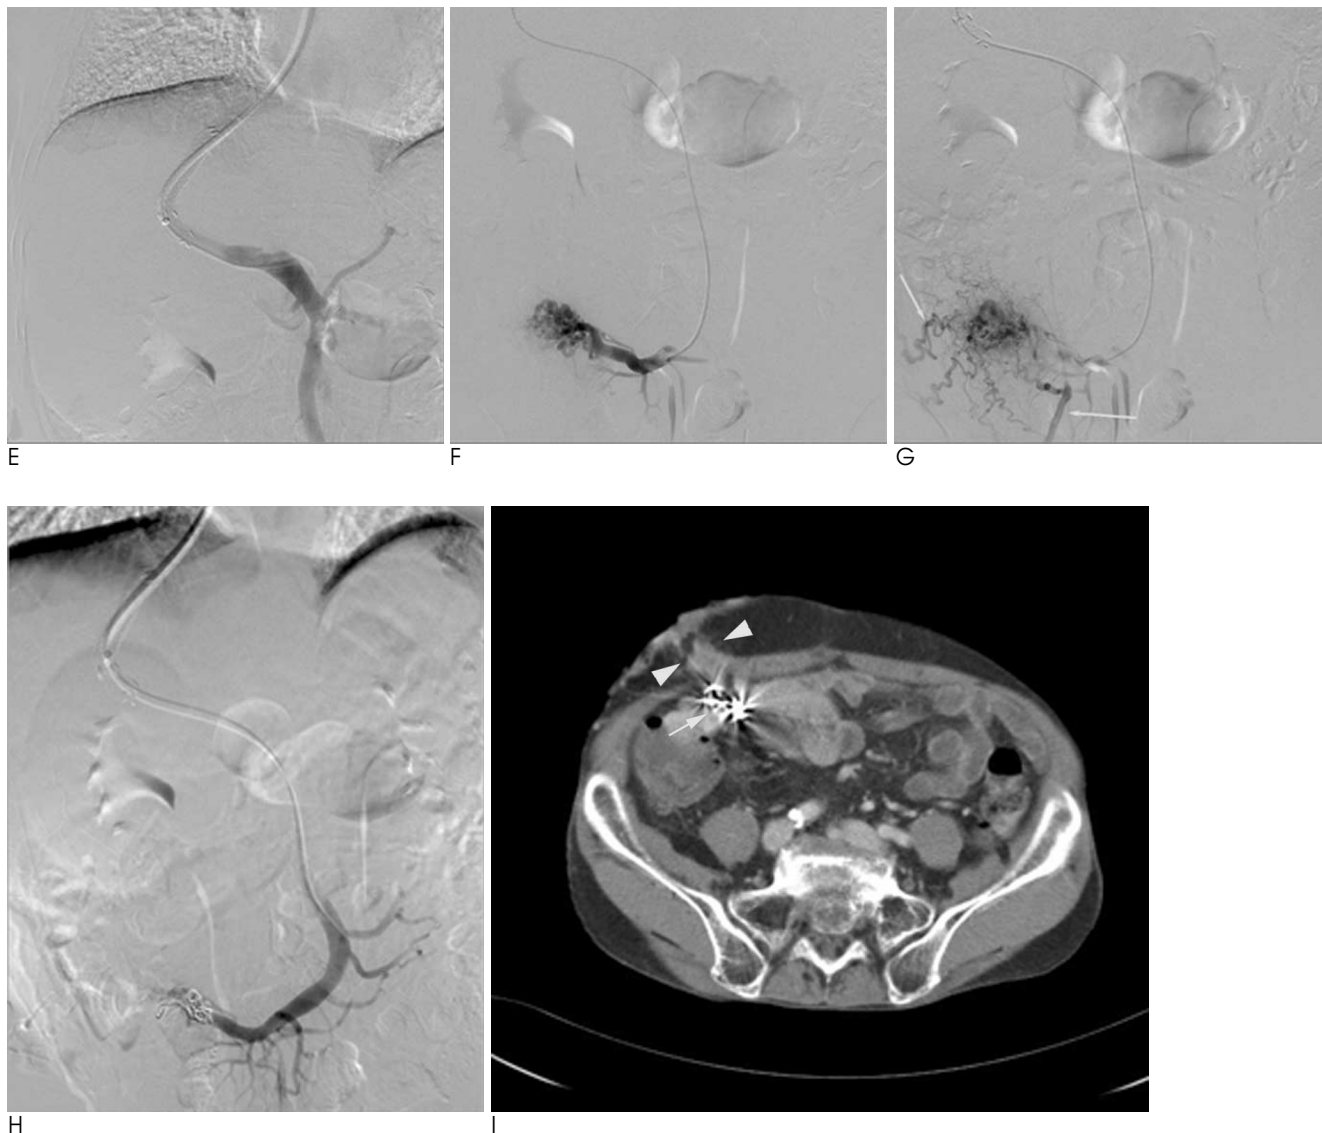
E-H. A subtracted transjugular portogram demonstrates the TIPS with coil embolization, in steps. (E) A portal venogram obtained after insertion of a TIPS stent-graft. (F) A well-developed stomal varix from an ileal branch of the superior mesenteric vein is noted. (G) A delayed image demonstrates systemic drainage (arrows) of the stomal varix. (H) After coil embolization of the stomal varix, there is no further bleeding and systemic drainage. I. The patient visited the hospital after five months for routine follow-up. (I) An axial CT image shows the presence of previously inserted metallic coils (arrow). There is no evidence of abnormal vessels around the stoma (arrowheads).
